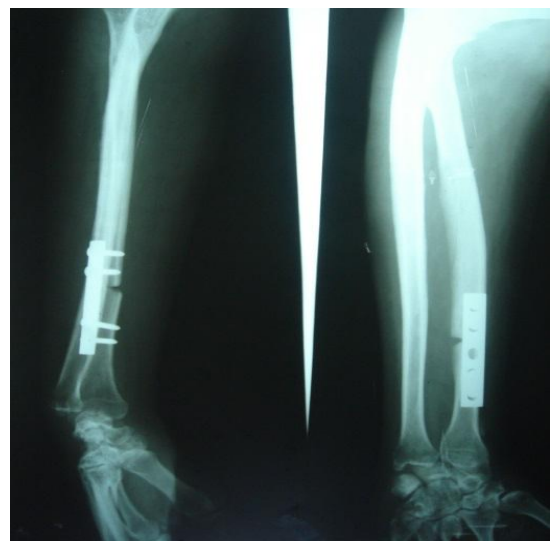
Post-operative x-ray, Graft inserted at the distal radius with DCP fixation.
